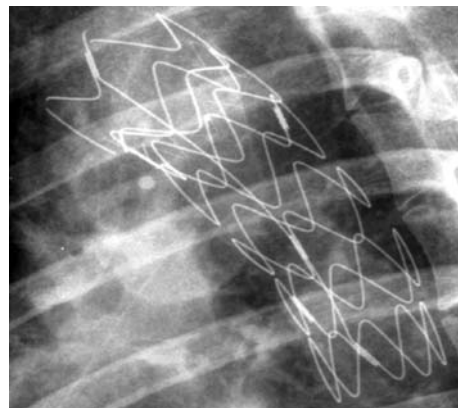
This simple plain film control at 5-years follow-up demonstrated the fractures of the nitinol filaments of the uncovered part of this Talent device
